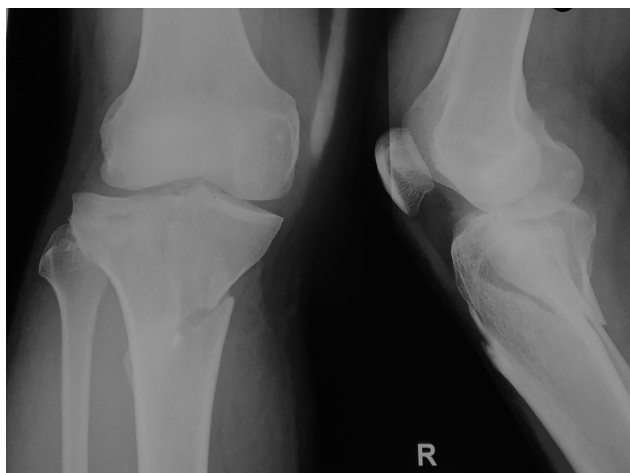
Radiographs of anterior-posterior (AP) and lateral view of Type VI fracture of a 44-year-old man.
